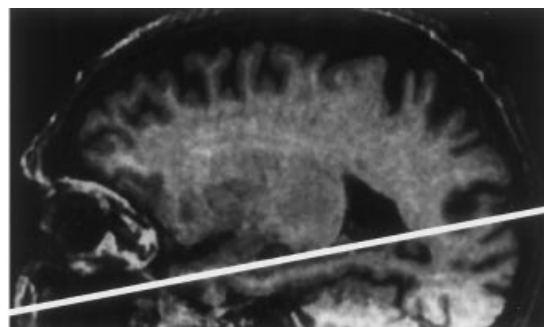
MRI using the 3-D method of gradient recall shows brain atrophy during normal aging of an 86-year-old athlete (lower left) compared with that of a 77-year-old patient with Alzheimer's disease (lower right). The atrophied areas look like two seahorses facing each other on either side of the central brain stem. These seahorselike structures are the hippocampi and are responsible for some memory functions.
